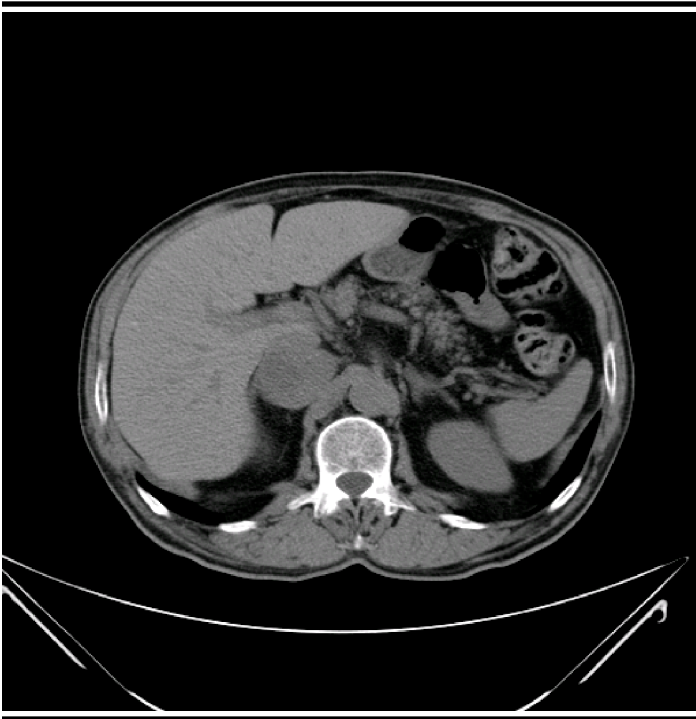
Computed tomographic scan of abdomen showing a 6 cm well encapsulated mass of right adrenal mass together with a clearly normal left adrenal gland.
